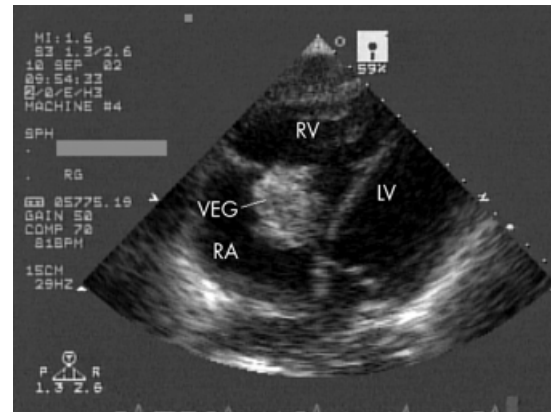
Echocardiographic image of a large vegetation, approximately 4cm in diameter, attached to the Tricuspid valve¹ (reproduced from Moss et al.)
